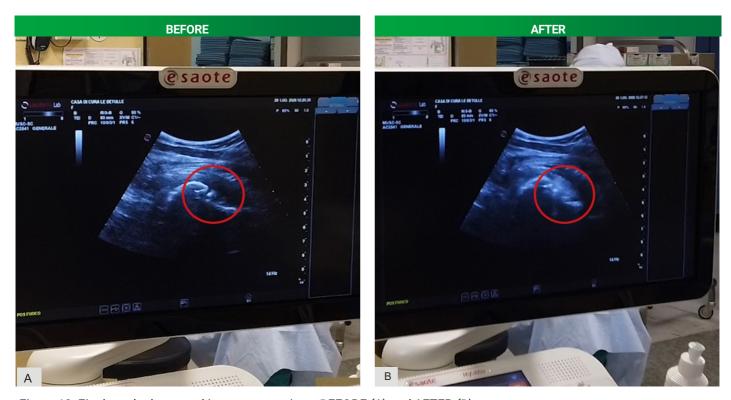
Final result ultrasound image comparison: BEFORE (A) and AFTER (B) treatment.
